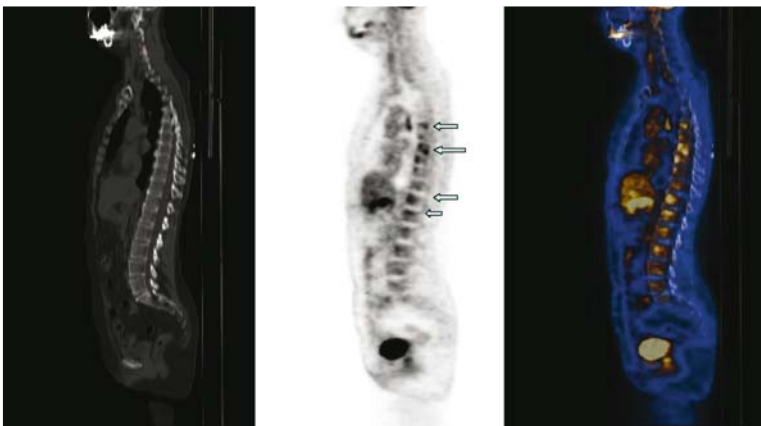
A 58-year-old patient, 9 years after mastectomy and adjuvant chemo- and radiotherapy for breast cancer, treated with hormonal therapy. Referred for assessment of elevated Ca 15-3 serum levels. PET (middle) and fused PET/CT sagittal images show increased FDG uptake in thoracic and lumbar spine (arrows) with no clear abnormality on the CT image (left). The hormonal therapy was stopped and chemotherapy was started. The patient died 2 years later of progressive metastatic disease
